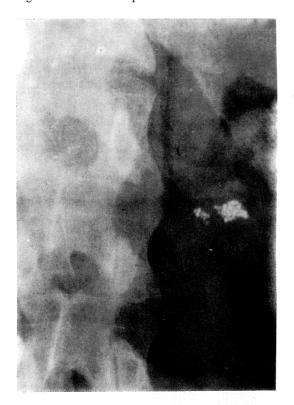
X-ray photographs of agar beads containing barium sulfate as a contrast substance in the gastro-intestinal tract (5 min.)
